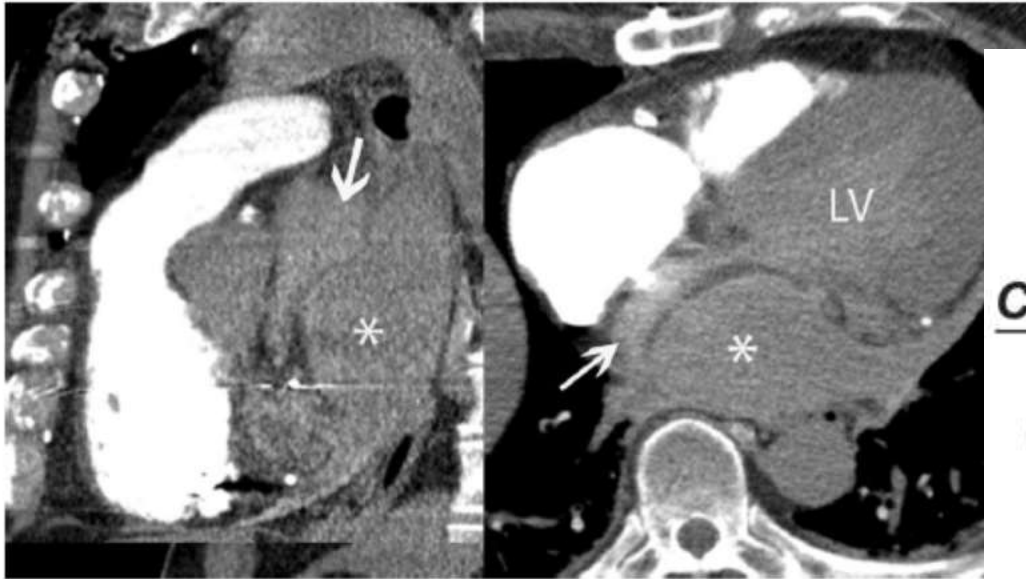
Cardiac CT (left = sagittal plane, right = axial plane). Arrow indicates compressive left atrium. Asterisk indicates hematoma.
